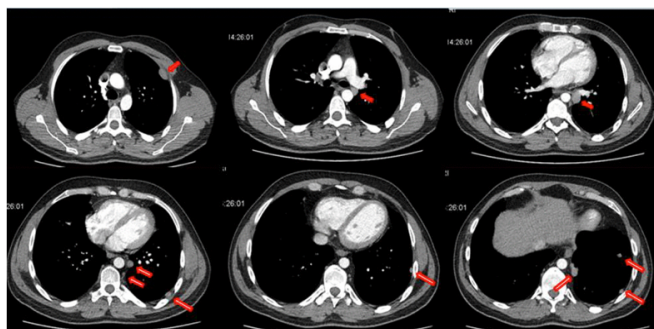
Thorax CT shows multiple round shape and homogenous lesions in the left hemithorax (red arrows).
